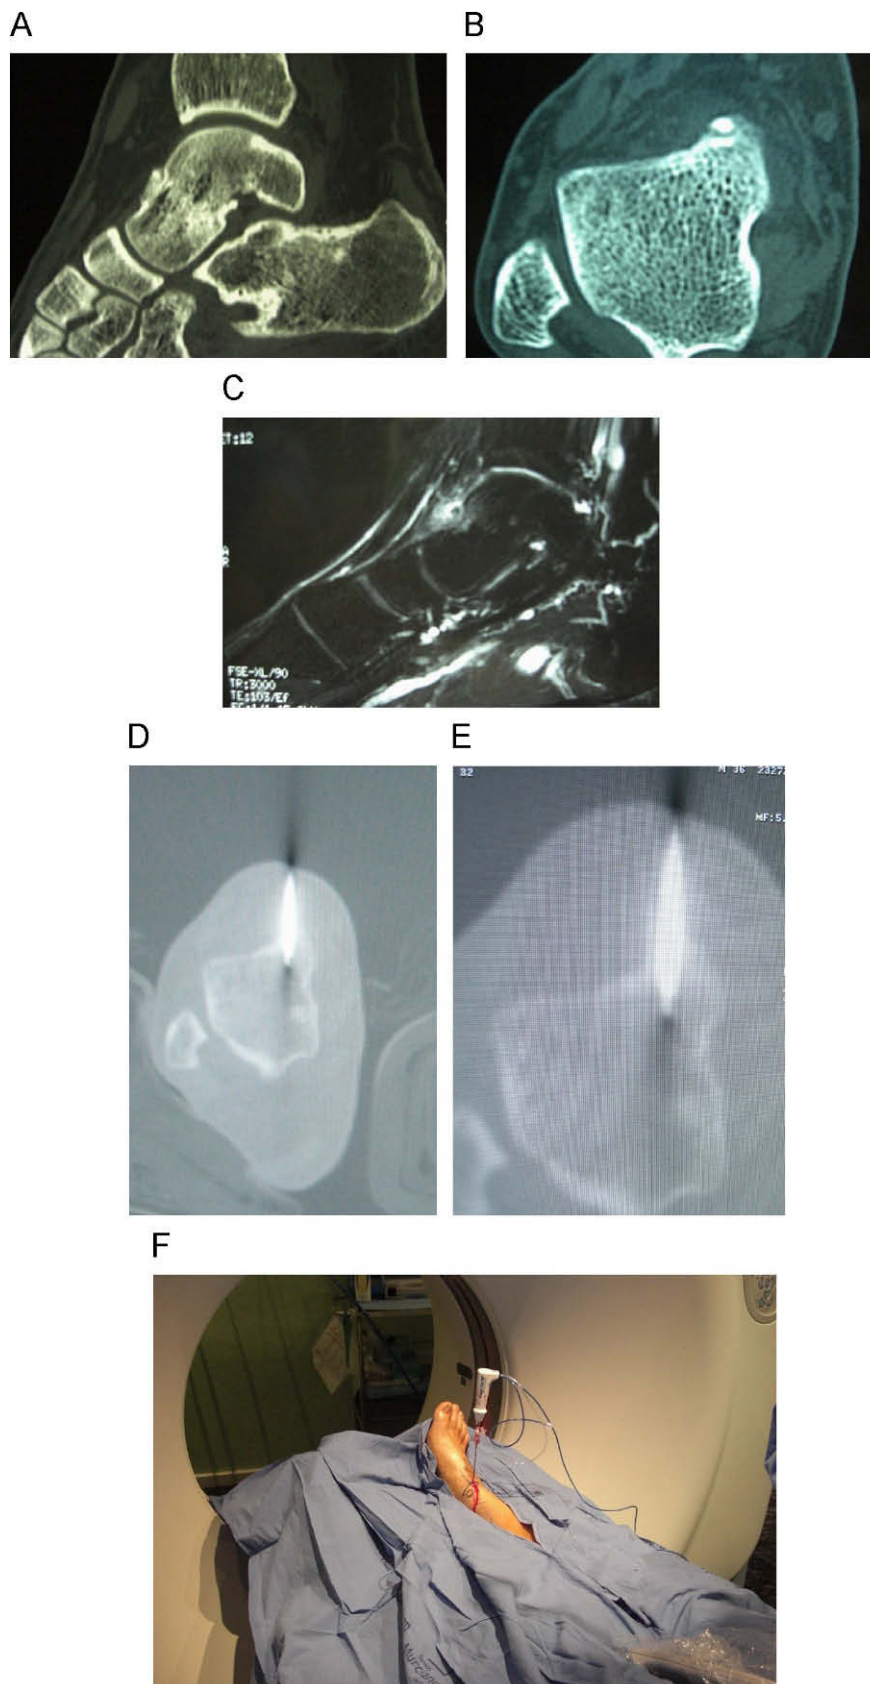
A) Sagittal slice CT image of an osteoid osteoma in the neck of the talus in a 38-year-old male. B) Axial slice of an osteoma. C) Location of the lesion using MRI. D) Insertion of the bone biopsy needle into the centre of the nidus. E) Verification of the radiofrequency needle placement. F) Patient on the CT gantry with the radiofrequency needle situated.
